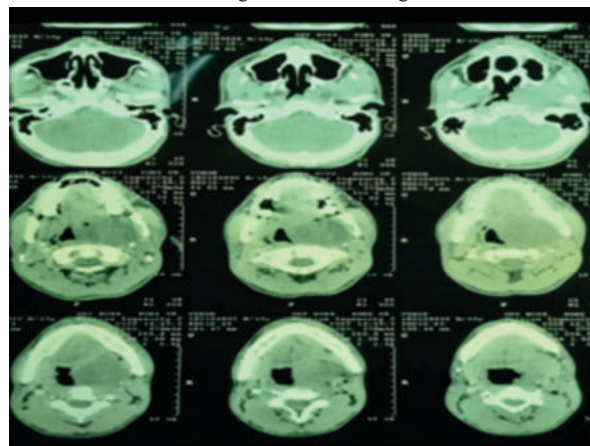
Pre-operative CT scan showing hypodense lesion
